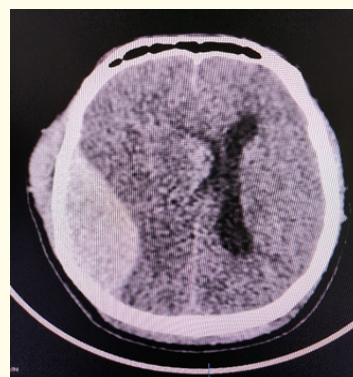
CT scan of the same patient showing a large lenticular-shaped hyperdensity in the right parietal region in the extradural location, causing a significant midline shift towards the left side, suggestive of an extradural haemorrhage. A hypodensity is noted in the right parietal lobe adjacent to the above-mentioned hyperdensity, suggestive of brain edema.
